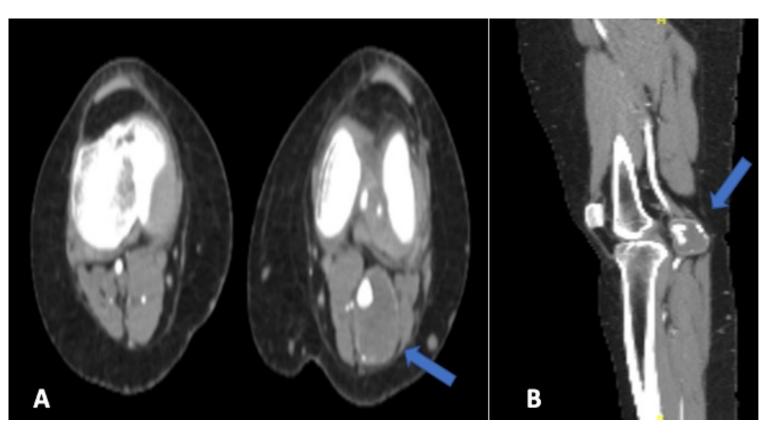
Computed tomography angiography of the lower limbs. (A) CTA axial section revealed a left popliteal artery aneurysm with a thrombosed sac behind the knee joint (arrowhead), and distally, all runoff exhibited showed good opacification. (B) CTA sagittal section of the same image.
